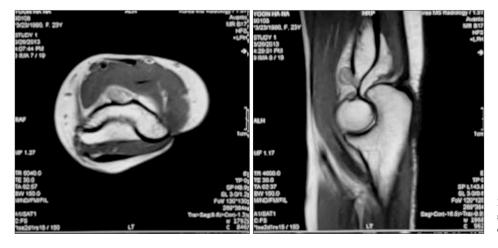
Magnetic resonance imaging images show intra-articular osteochondroma with cartilaginous cap.
